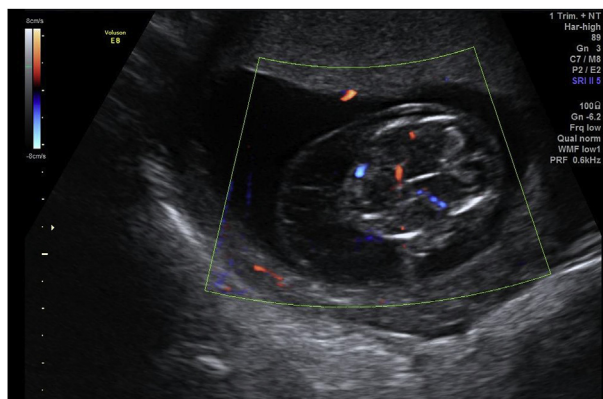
Color Doppler ultrasounds of cystic hygroma showed no internal flow.
